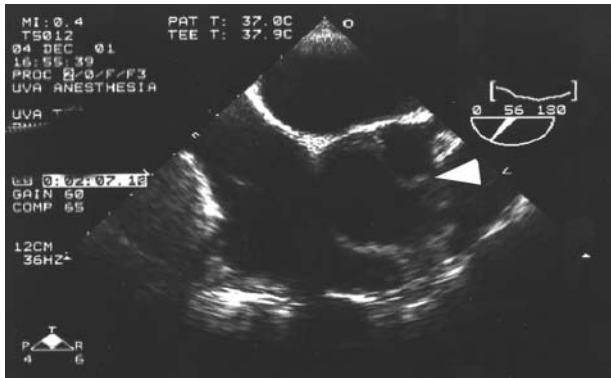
Transesophageal echocardiographic image of an acute type A dissection. The dissection flap (arrowhead) within the lumen of the aortic root included one aortic valve commissure and freely prolapsed through the aortic valve orifice during diastole.
